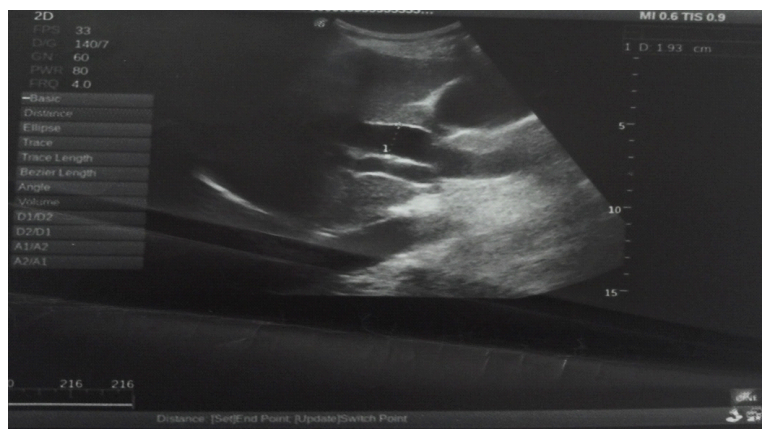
Ultrasound image of 34years female showing dilated CBD.
